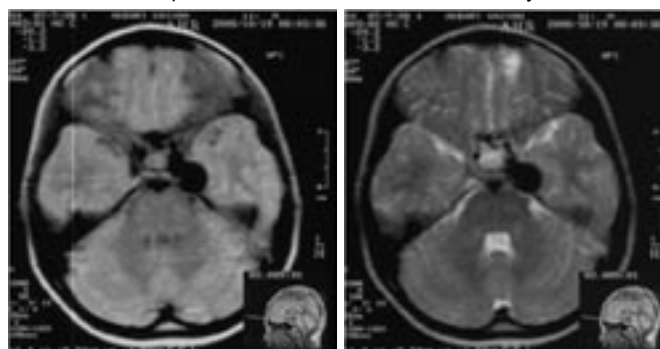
MRI reveals round signal void focus in the left cavernous region compatible with aneurysm
